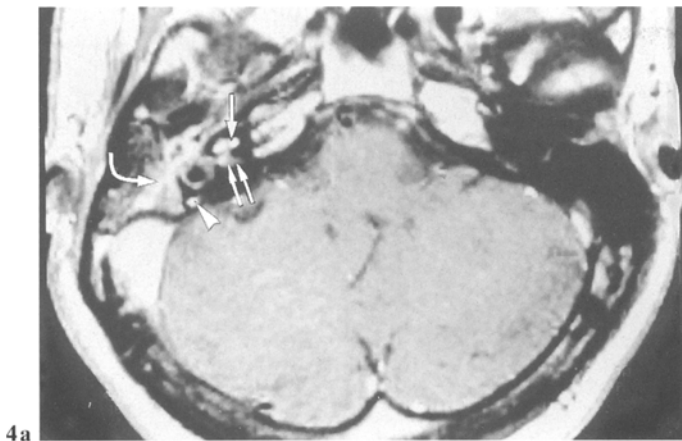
Inflammatory bacterial labyrinthitis. Axial enhanced T1WI (a) and T2WI (b) MR images of an 18-year-old man with a history of sudden vertigo followed by acute deafness. a The cochlea (*arrow*) and the posterior semicircular canal are intensely enhanced (*arrowhead*). Note the spread of the enhancement through the IAC (*double arrows*). Enhancement of the middle ear and the mastoid cells (*curved arrow*). b The obliteration of the membranous labyrinth is attested by an almost complete loss of the normal high signal intensity (SI; *arrows*). Intermediate SI of the middle ear and mastoid cells (*curved arrow*); normal aspect of the acoustic-vestibular nerves (*double arrows*)
